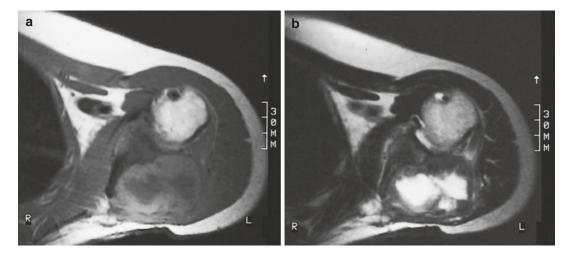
(a, b) Recurrent nodular fasciitis of the fascial type in a 37-year-old woman. (a) Axial spin-echo T1-weighted MR image. (b) Axial spin-echo T2-weighted MR image. Well-delineated, oval mass within the region of the infraspinatus muscle, adjacent to the scapula. The lesion is hyperintense to muscle on the T1-weighted
